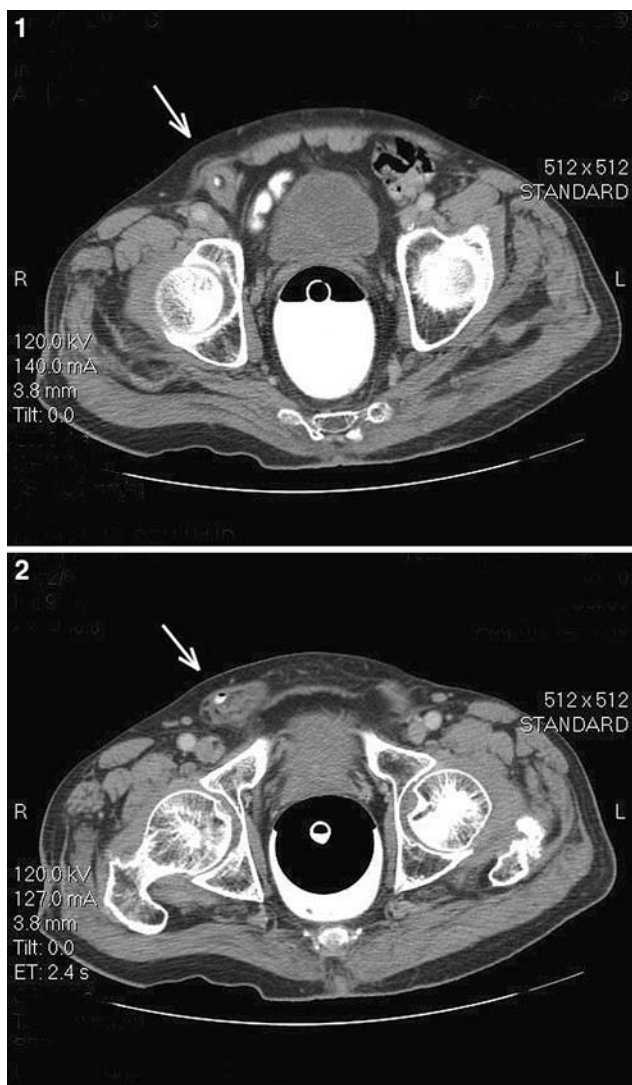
2 CT-scan findings in Amyand's hernia in two different patients. Note the contrast-filled appendix in the right inguinal canal (white arrows)
